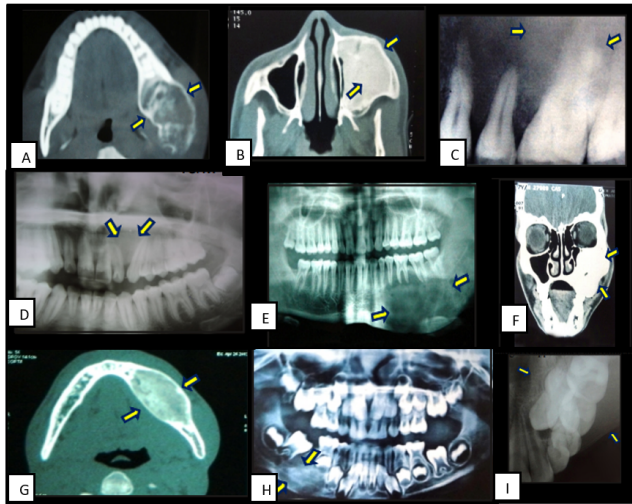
Variation in radiographic finding of fibrous Dysplasia A): Mixed radiolucency extending from distal 36 to ramus; B): Matured lesion appeared with increasing radiopacity; C): Ground glass Appearance; D): Divergence of Root with 22 & 23; E): – Displacement of canal with inferior border of left side of mandible; F): Radiopacity of lesion extending upto orbital floor; G): Fusiform mixed radiolucency with ground glass appearance. H& I): poorly defined border which classically merge with adjacent bone
